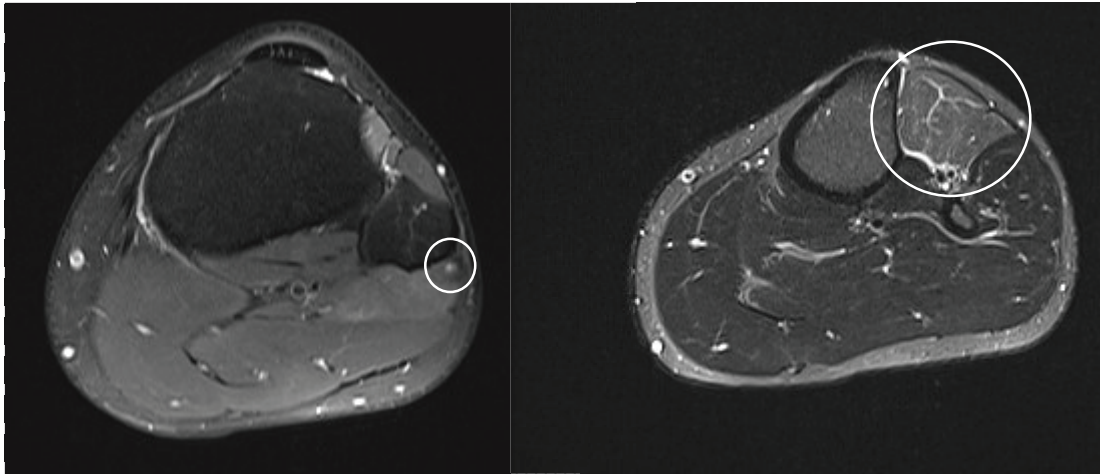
A. Edematous left peroneal nerve on axial proton density weighted MRI, B. Edematous left tibialis anterior muscle on axial STIR
